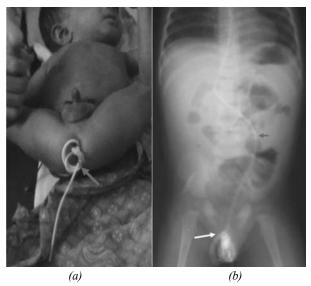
(a) Infant with 'bunch of coils' of shunt tube protruding through the anus with securing sutures in situ (red arrow); (b) Abdominal X-ray showing point of shunt entry into the sigmoid colon (red arrow) and shunt coils lying in the perianal region(white arrow).
